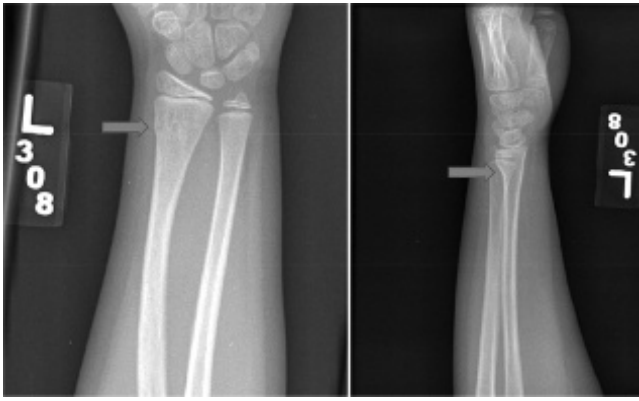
AP and lateral radiographs of the wrist demonstrate a buckle fracture of the distal radius metaphysis.
